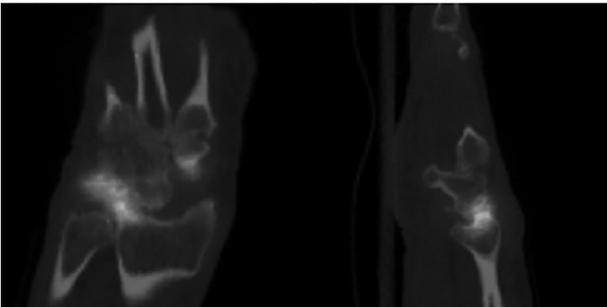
Bone-scan with addition of the CT shows a significant signal increase at the site of the impingement
